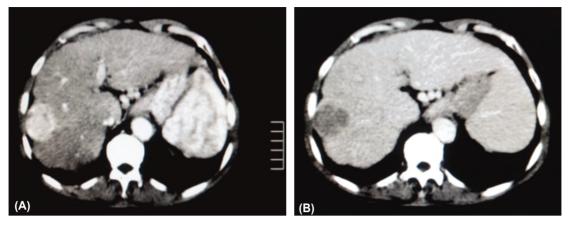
Diagnosis of HCC. Computed tomographic scan of HCC shows contrast enhancement in the early arterial phase (A) and hypointensity in the portovenous phase (B).
